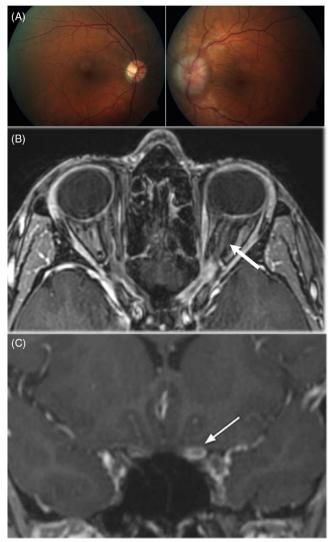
(A) Fundus photographs of right and left eye; the left eye shows marked, circumferential optic disc edema and choroidal folds. Left optic sheath enhancement (white arrow) on T1 FS, (B) axial and (C) coronal MRI.
